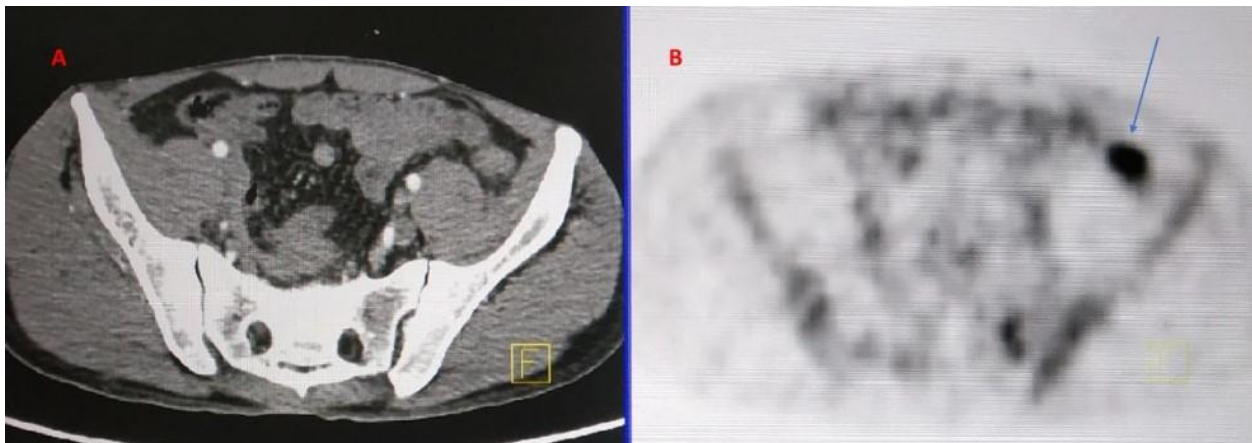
A) Axial CECT image does not show any enlarged lymph node or abnormal enhancing lesion in the region; B) Axial PET image shows increased FDG uptake corresponding to bowel loop in the CECT image which is showing false positive uptake (blue arrow) without any pathological involvement.
